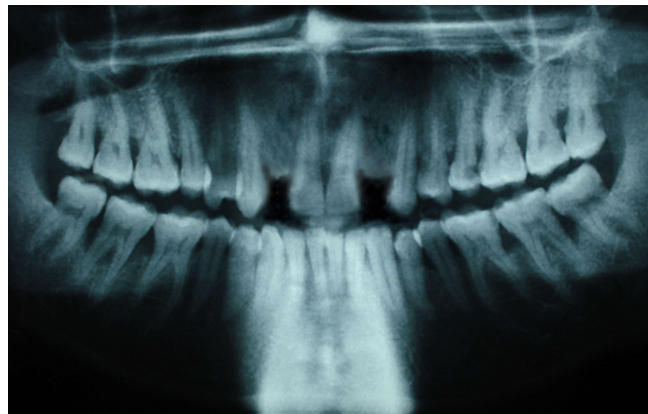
Orthopantomogram (OPG) showing a combination of horizontal and vertical bone loss.
